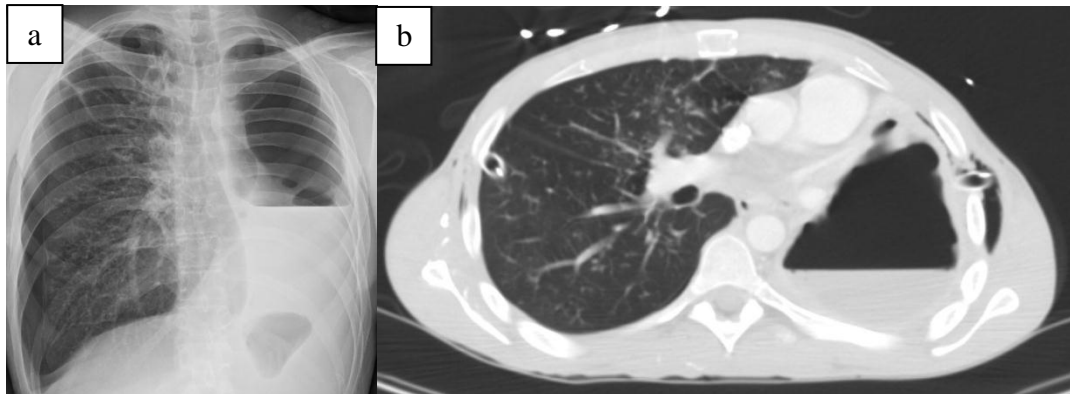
(a) Chest x-ray revealed bilateral spontaneous pneumothorax. (b) CT of the chest showed diffuse lung cysts.
